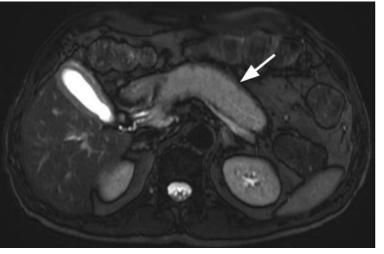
Axial MRI image of the upper abdomen.
